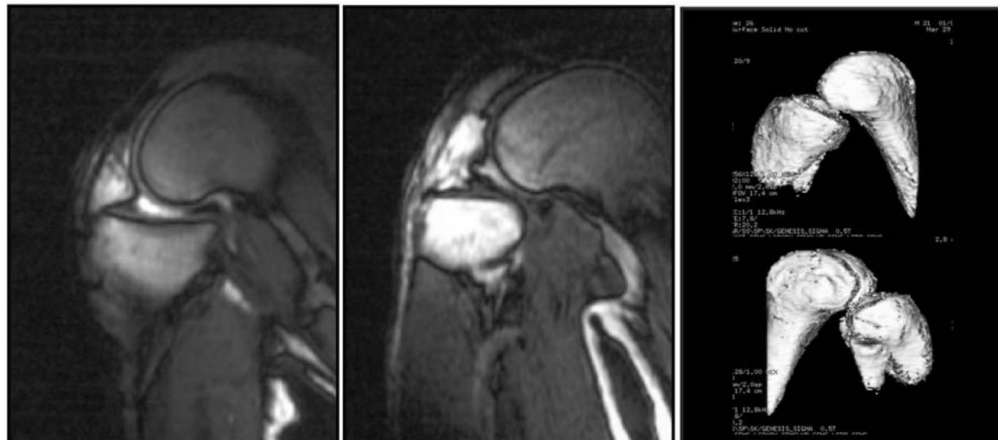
Interventional MRI scans for Knee ROM from Johal et al. [7]
